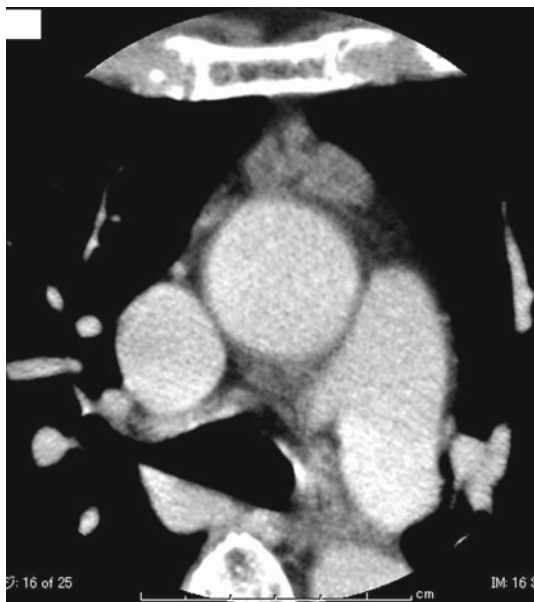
Enhanced CT of the mediastinum showing an anterior mediastinal nodule (20 × 8 × 14 mm) with an irregular multilobular rim. After administration of 50 ml of contrast material infused during 30 min, the lesion attenuation was elevated from 35 HU to 81 HU. The thymus was thought to be included in the nodule
